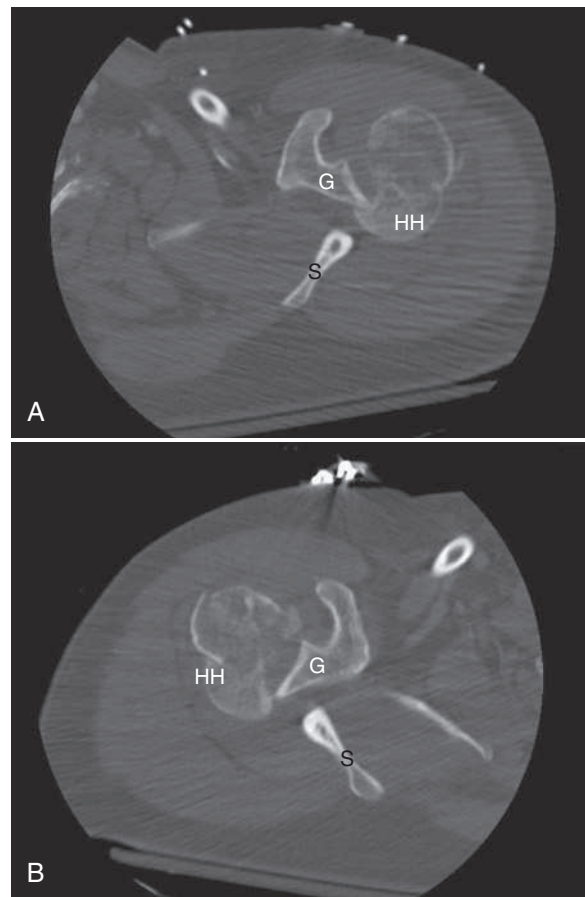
Bilateral proximal humeral fractures and posterior dislocations that occurred when an ultramarathoner suffered a seizure during a race. Computed tomography scan of right and left shoulders demonstrating posteriorly dislocated humeral heads, perched on respective glenoids. G, Glenoid; HH, humeral head; S, scapula.
